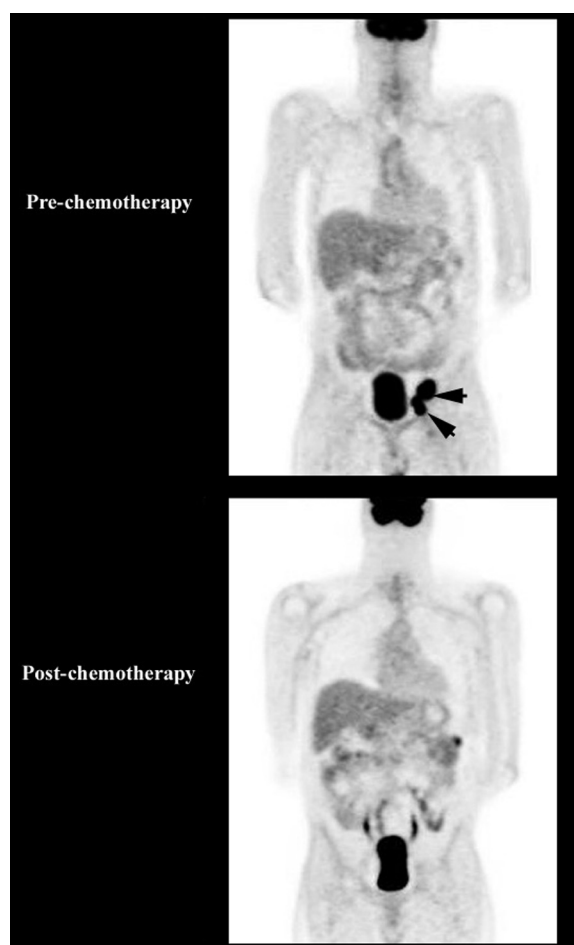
On baseline PET scanning of a patient with widely metastatic malignant melanoma obtained before planned chemotherapy (above) a representative coronal image plane demonstrates foci of intense uptake in the left external iliac nodal stations (arrows) and at other sites not displayed in this plane. The iliac nodes measured up to 15 mm. Following three cycles of chemotherapy there was no change in the CT appearances but PET suggested a complete metabolic response (below). While cure is unlikely in this clinical setting, a favourable metabolic response encouraged ongoing therapy and may have prognostic implications. Normalisation of the images on hepatic activity enables qualitative evaluation of response.
